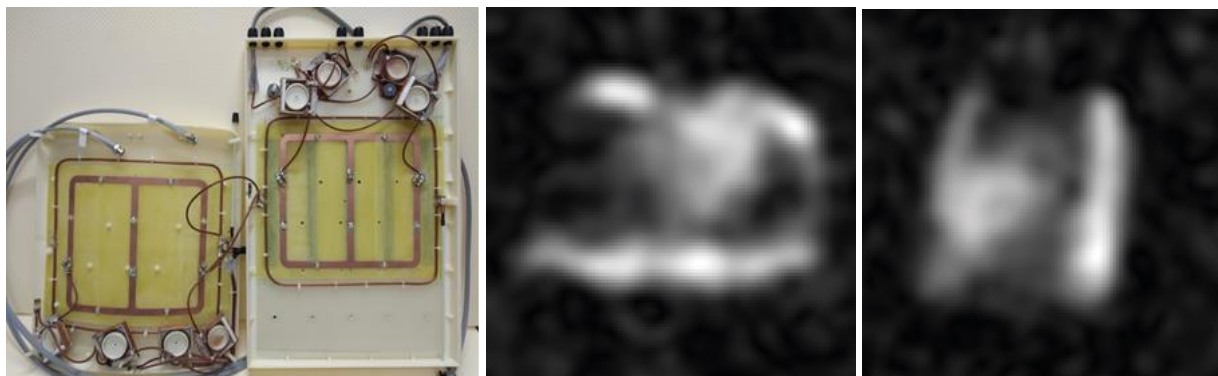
Anterior (left) and posterior part (right) of the RF coil which was used for $^{39}\text{K}/^1\text{H}$ MRI in our feasibility study.
